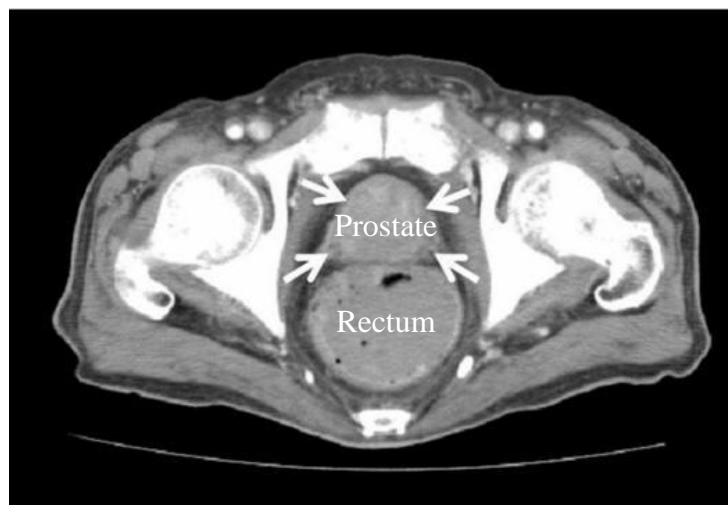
CT scan of prostate in pelvis. This scan shows an enlarged prostate with cancer above the rectum. These scans are used for treatment planning [14].
